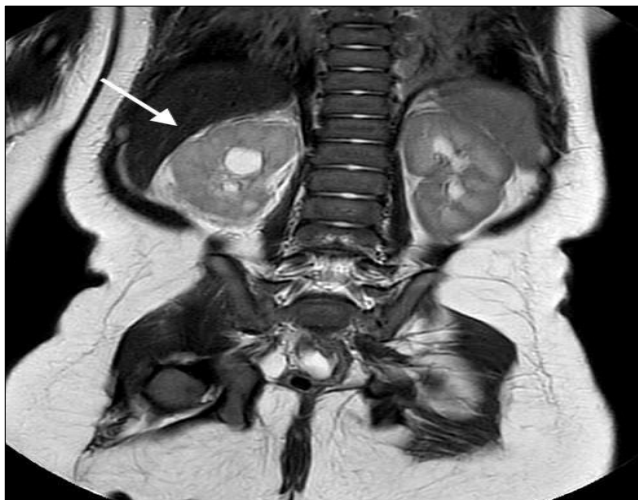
Post-operative MRI: coronal view. The right pelvis and ureter appeared normal (white arrow).
